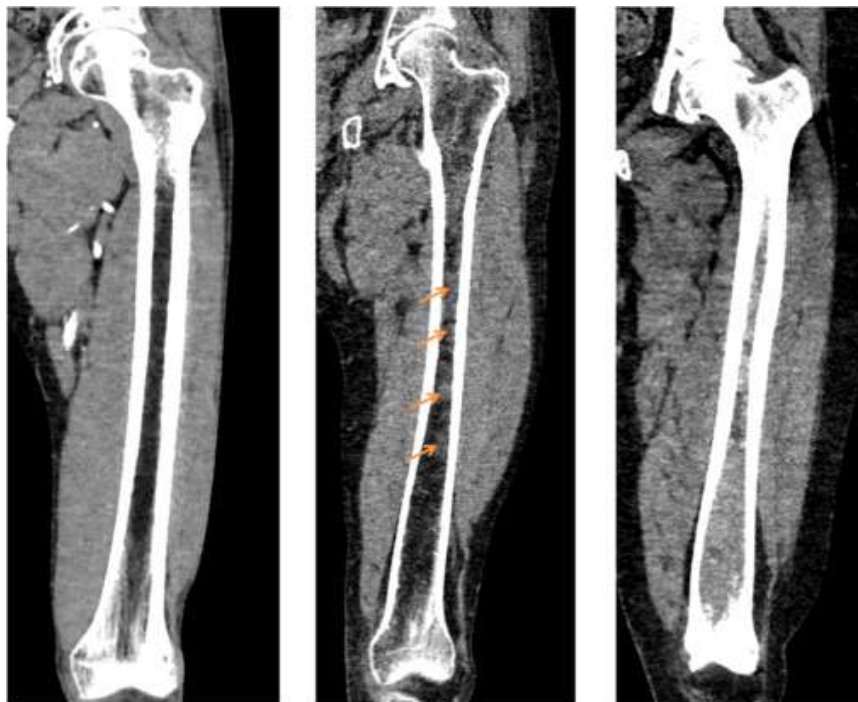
Shows the bone marrow at CT scan.
